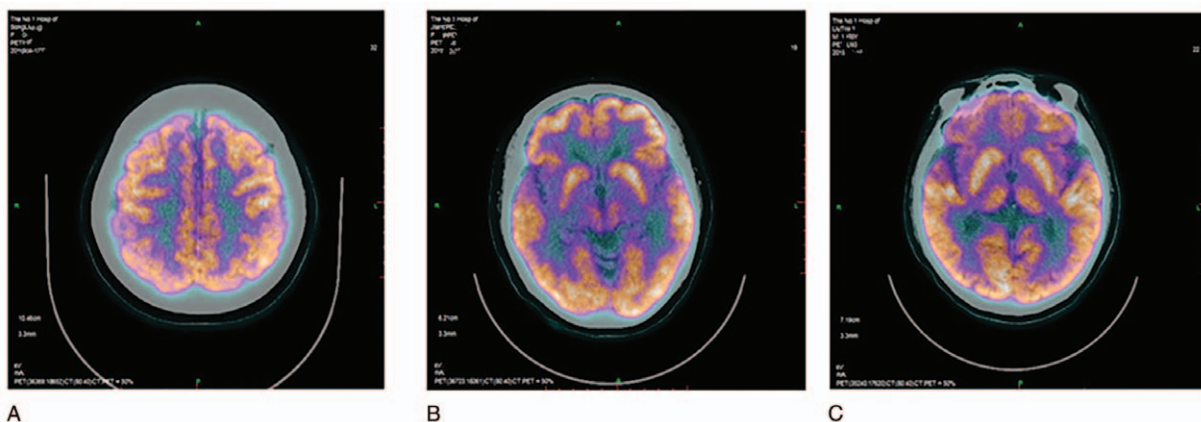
^{18}F -FDG PET/CT imaging (A): Reduced parietal metabolism in patients; (B): increased symmetric radioactivity distribution of bilateral basal ganglia; (C): reduced temporal lobe metabolism. ^{18}F -FDG = 18 -Fluorine flurodeoxyglucose, PET/CT = positron emission tomography/computed tomography.
